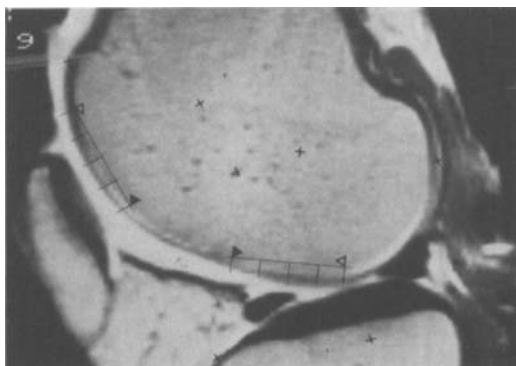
MRI, SE 700/15 (A), MR-Arthrography, SE 700/15 (B). The determination of the surface- and cartilage-thickness (A+B) drawn in by the assessor.
